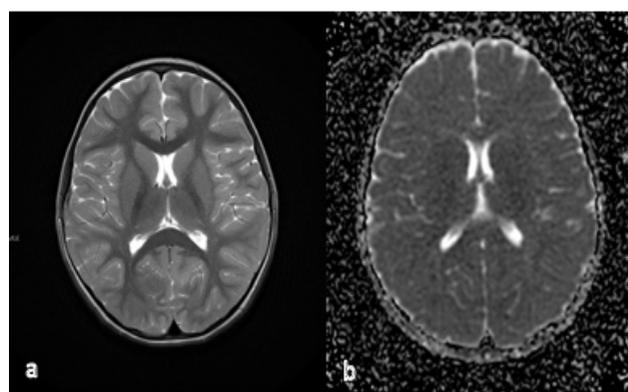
Follow-up cranial magnetic resonance images demonstrating the resolution of the splenial lesion. Axial T2-weighted (a) and apparent diffusion coefficient map (b)
